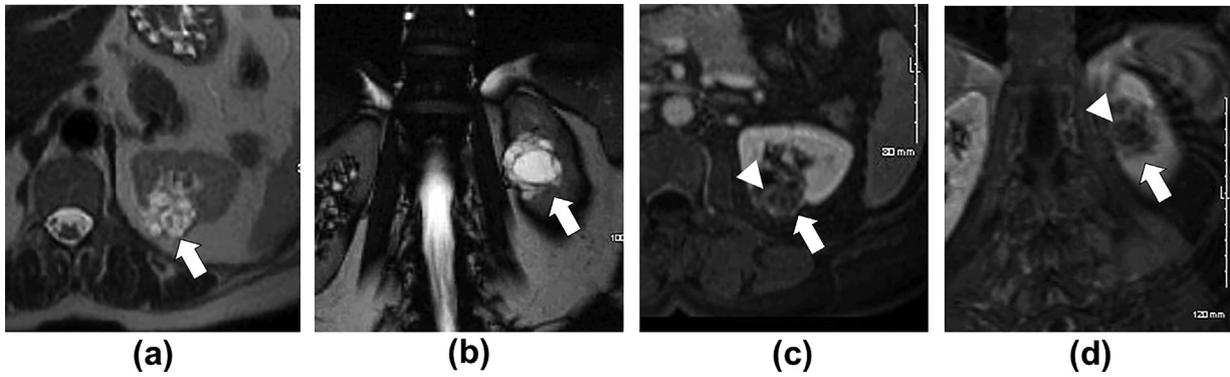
A 60-year-old female patient with cystic nephroma. (a) Axial and (b) coronal FS T2-weighted images show a predominantly cystic mass in the interpolar region of the left kidney (arrows). The mass shows several thin internal septa (arrowheads) on the (c) axial and (d) coronal T1-weighted FS gadolinium-enhanced images. The mass was characterised as a Bosniak Type 3 cyst. Diagnosis of cystic nephroma was confirmed after total nephrectomy.
